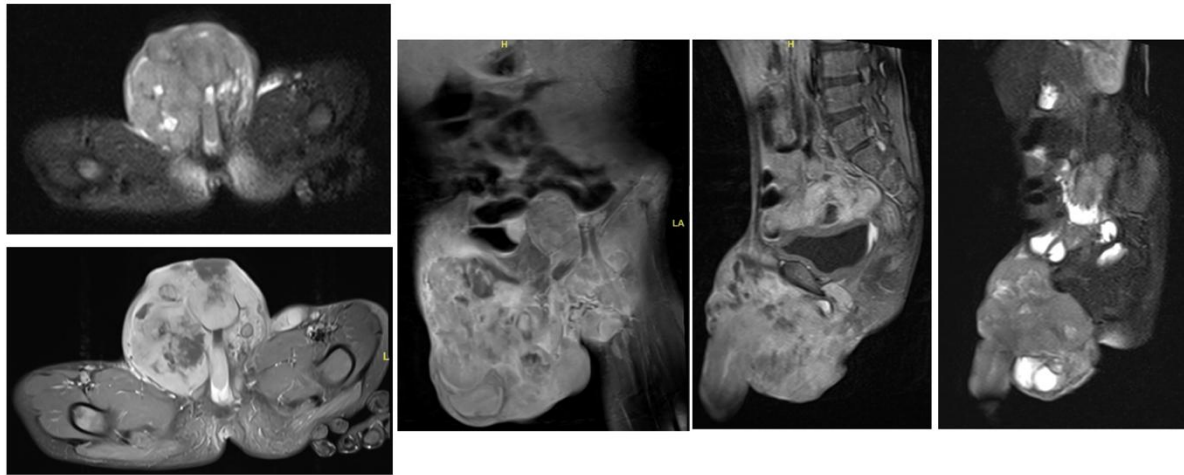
Pelvic MRI with Contrast.
